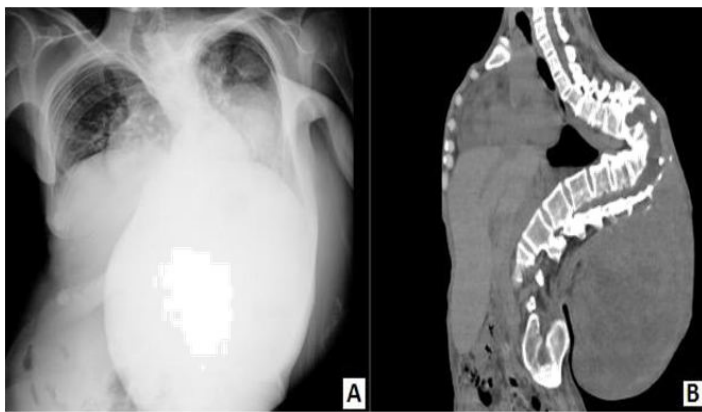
A huge mass at left back and right paraspinal region, at the level of T7 to S4 level. It mainly located in subcutaneous layer, but with intraspinal extension to left side T8-10 spinal canal, suspicious bilateral paraspinal muscles invasion at the T7-L1 level. (A)X-ray, (B)Computed tomography.
